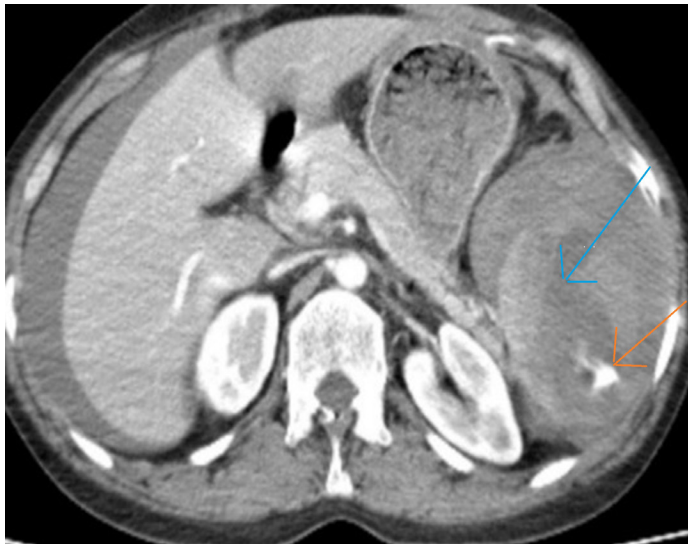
Axial CT section. Blue Arrow: Active splenic hemorrhage, Orange Arrow: Splenic laceration
